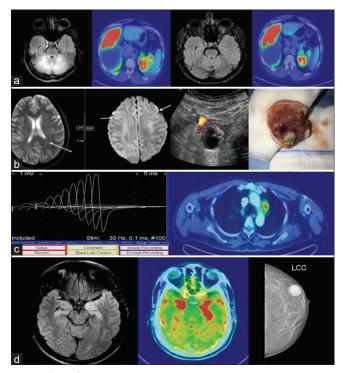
a) 37-year old man with subacute cerebellar ataxia and pancreatic neuroendocrine tumor with liver metastasis. MRI shows cerebellar swelling and hyperintensities; GA-68 DOTATATE-PET scan shows hypermetabolism in the tail of the pancreas and liver; treated with immunotherapy and Leutitium therapy for tumor. Repeat imaging after 1 year shows the disappearance of cerebellar hyperintensity with a mild reduction in metastasis. b) A 20-year old lady with NMDAR encephalitis; MRI shows an ovarian mass, and gross section suggestive of ovarian teratoma. c) 40-year old smoker with fatiguability, diagnosed to have LEMS based on RNS showing incremental response at 30 Hz, PET CT shows lung metastasis-biopsy was suggestive of small cell carcinoma lung. d) 50-year old lady with limbic encephalitis; MRI shows medial temporal lobe hyperintensities; FDG-PET scan shows hypermetabolism in corresponding areas, and mammogram suggestive of breast malignancy
